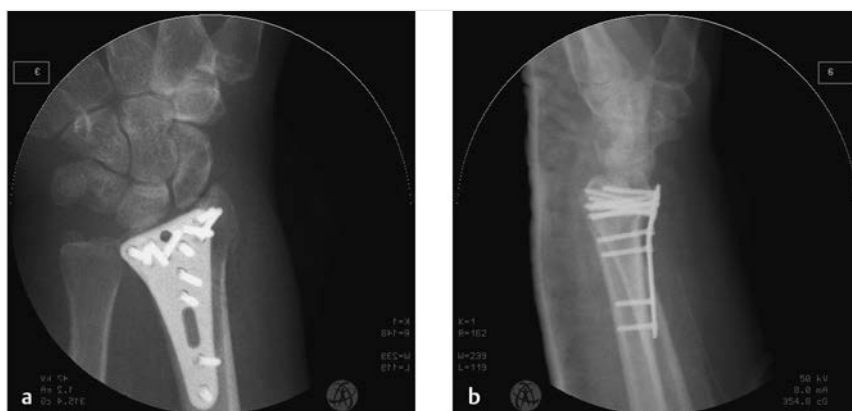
(a, b) Open reduction and internal fixation with a fixed-angle plate was performed. The postoperative X-ray showed a good result.
